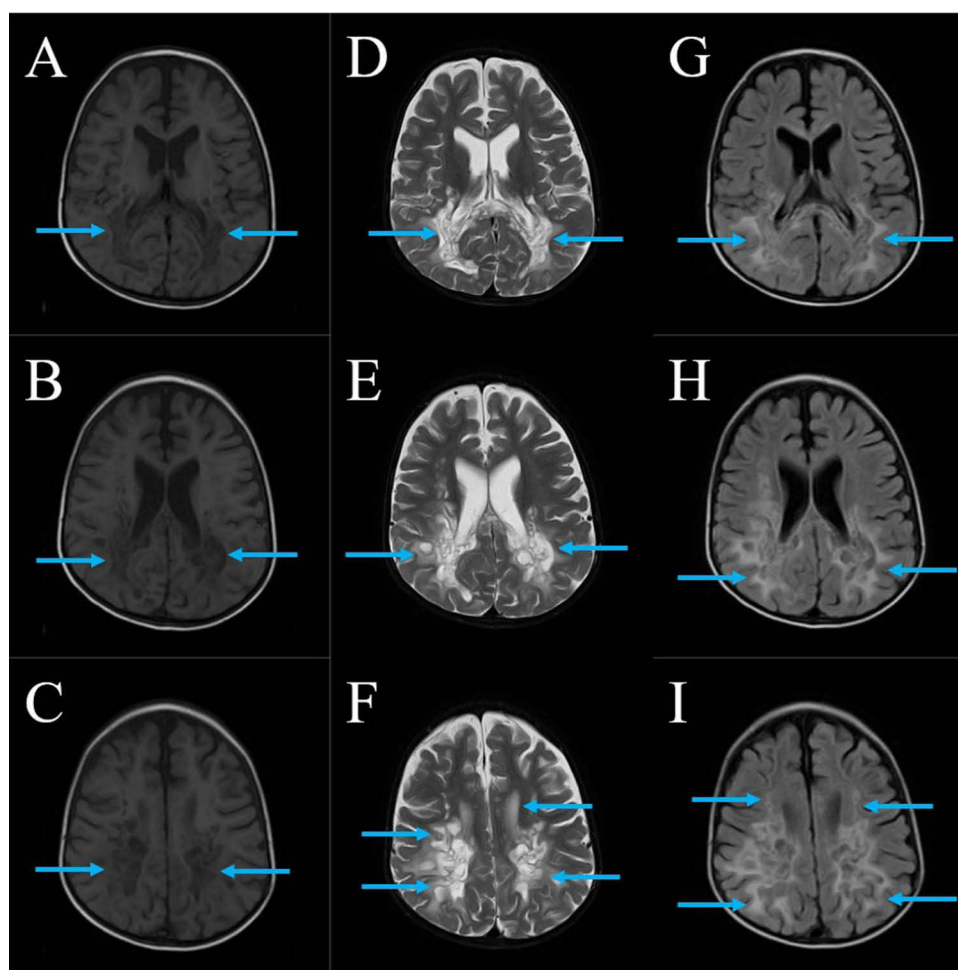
MRI (Plain) of the Brain. (A–C) are T1-weighted; (D–F) are T2-weighted; (G–I) are FLAIR-weighted. (A–C) show hypointense regions and (D–I) show hyperintense regions in the periventricular white matter with multiple cystic spaces. The splenium of corpus callosum is also involved. Blue arrows mark the abnormal regions.
